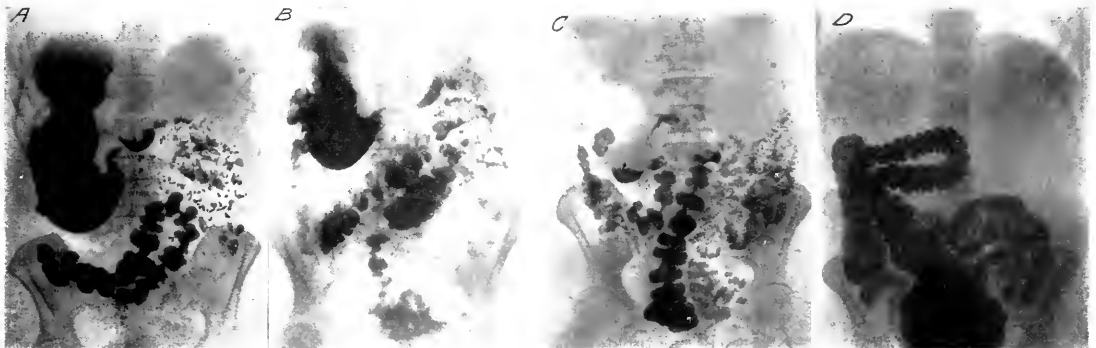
A, Immediate and twelve hour roentgenogram showing third case of non-fused, non-rotated cecum with deficient migration. (Plate taken with patient in erect position.) B, Immediate and twelve hour plate of same patient on re-examination. (Plate taken in erect position.) C, Six hour roentgenogram of same patient. D, Barium enema plate of same patient. (Plate taken in prone position.)
